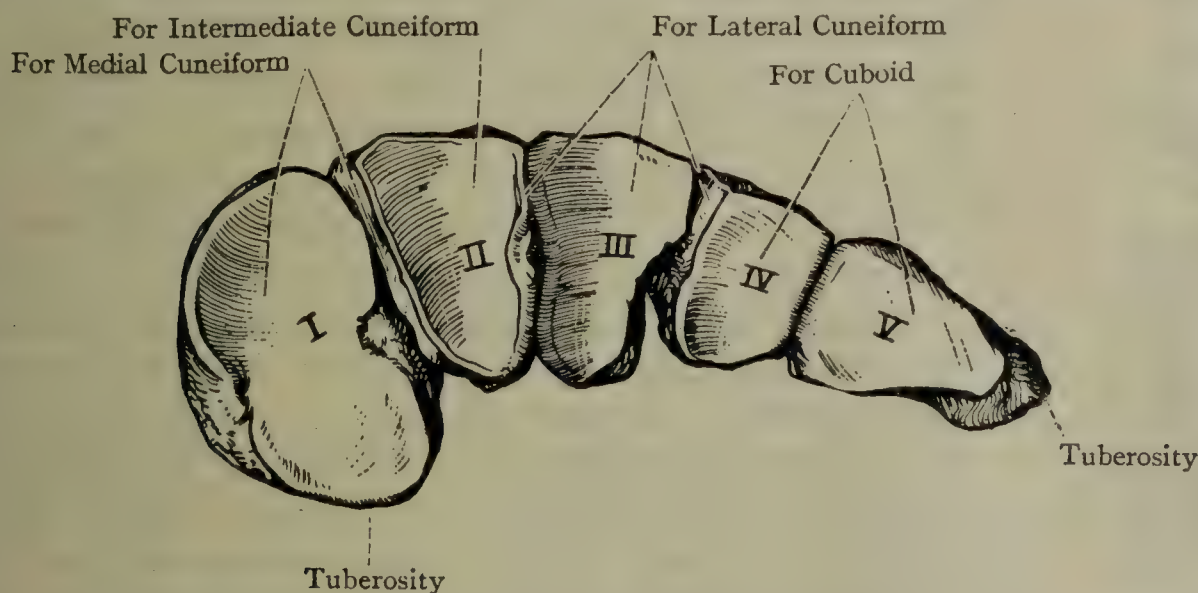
THE BASES OF THE RIGHT METATARSAL BONES (POSTERIOR ASPECT).
